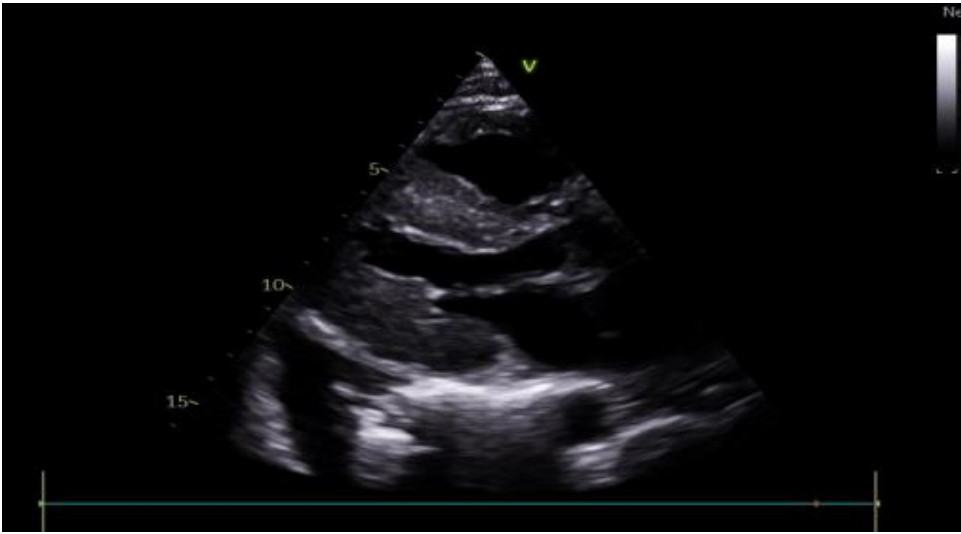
Parasternal long-axis view on echocardiography demonstrates diffuse concentric left ventricular hypertrophy
